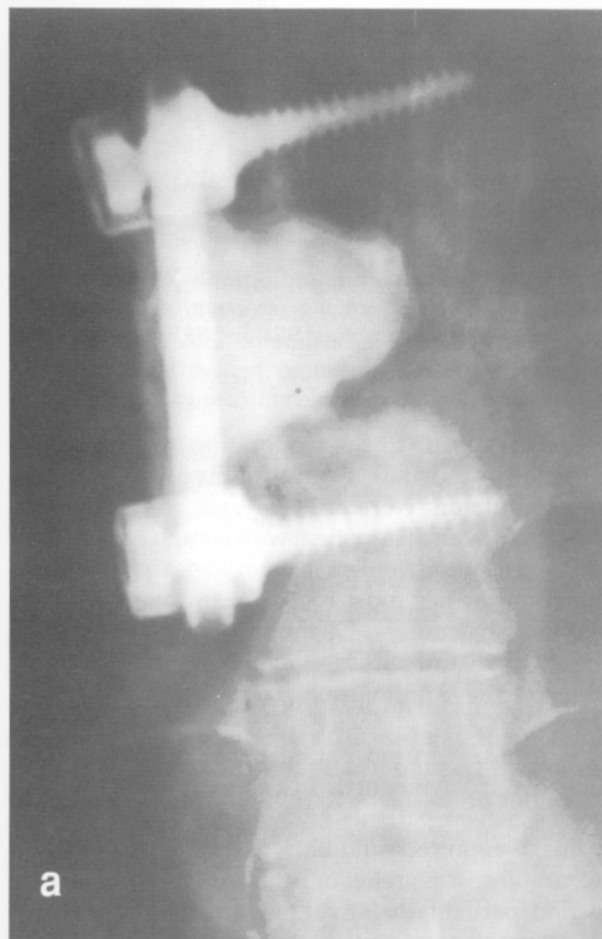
a) Postoperative anteroposterior radiograph demonstrating the methylmethacrylate-SRF construct, b) The FVM device was an another system used in this study as a SRF system.
